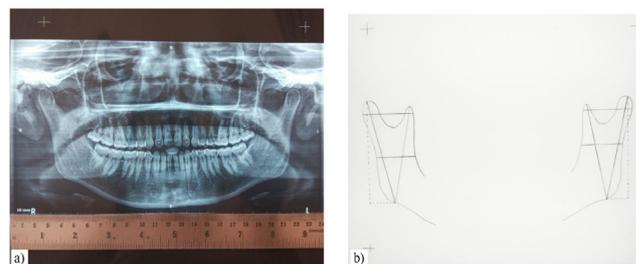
a) Orthopantomogram, b) Mandibular ramus tracing on matte acetate tracing paper.
